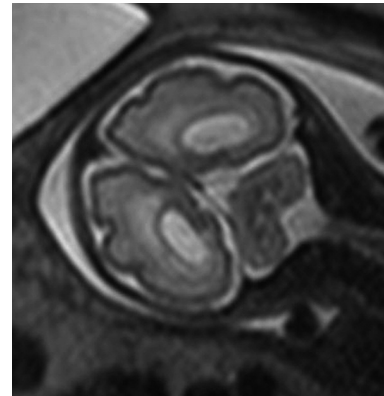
T2-weighted axial image (gestational age 30 weeks) in a proven case of congenital Cytomegalovirus showing borderline ventriculomegaly (atrial diameter 10 mm) and periventricular leucomalacia (marked hyperintense signal of the white matter tissue around the ventricular borders).
